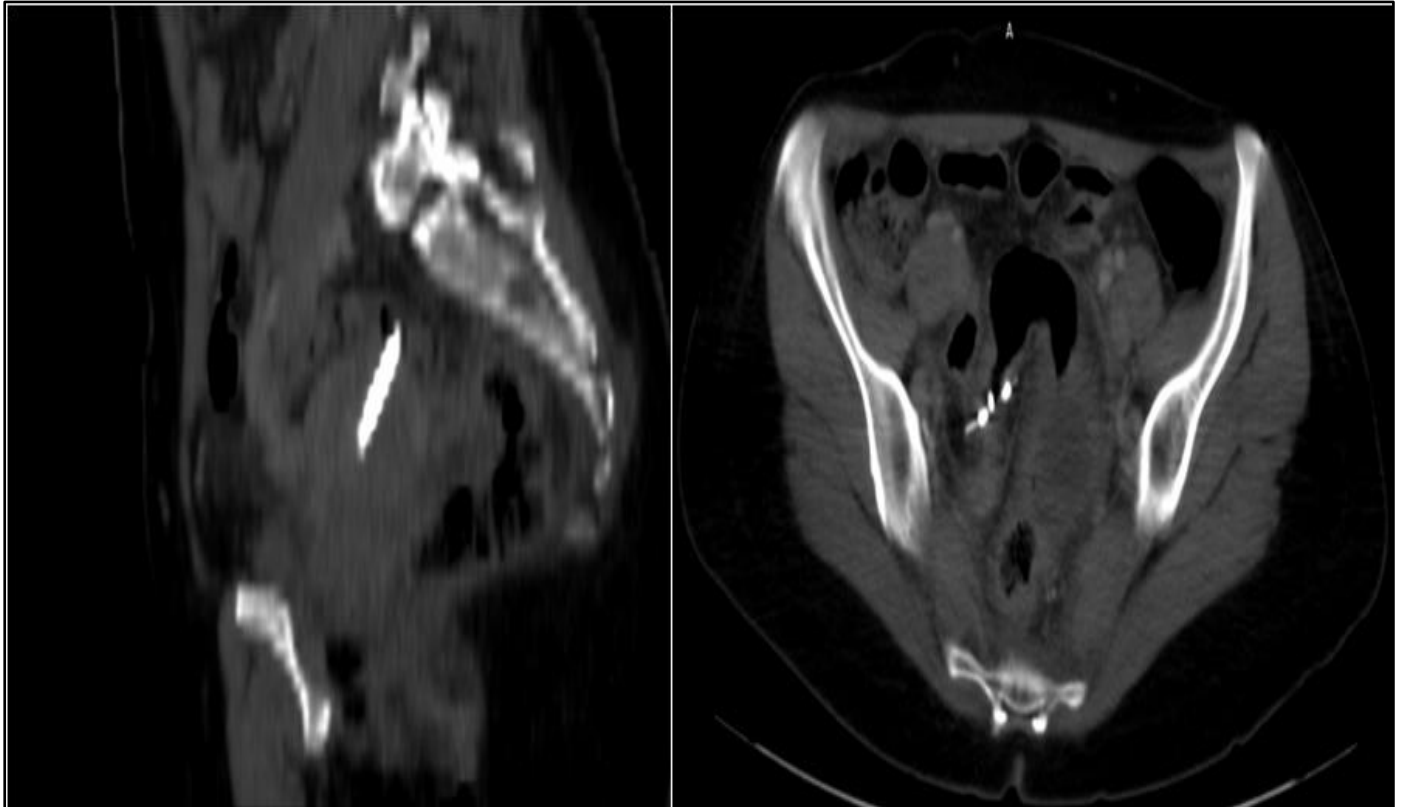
Sagittal and Longitudinal CT Scan Images Showing Extrauterine Migration of the IUD. The Stem Perforates the Anterior Rectal Wall Without Fecal Leakage (3).
